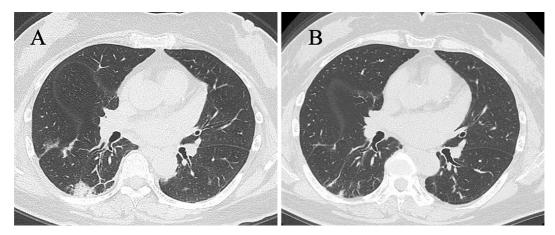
Interstitial lung disease on chest CT before and after treatment. Bilateral linear reticular shadows as well as a patchy shadow just below the pleura were identified by chest CT before treatment (A) and markedly improved after one month of combined immunosuppressive therapy that included prednisolone, tacrolimus, and intravenous cyclophosphamide (B).
